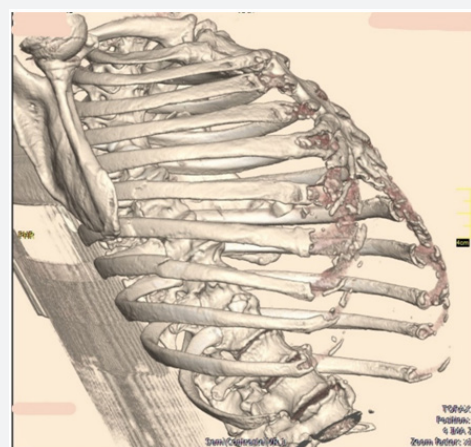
3D reconstruction Computed Tomography showing the fractures.
